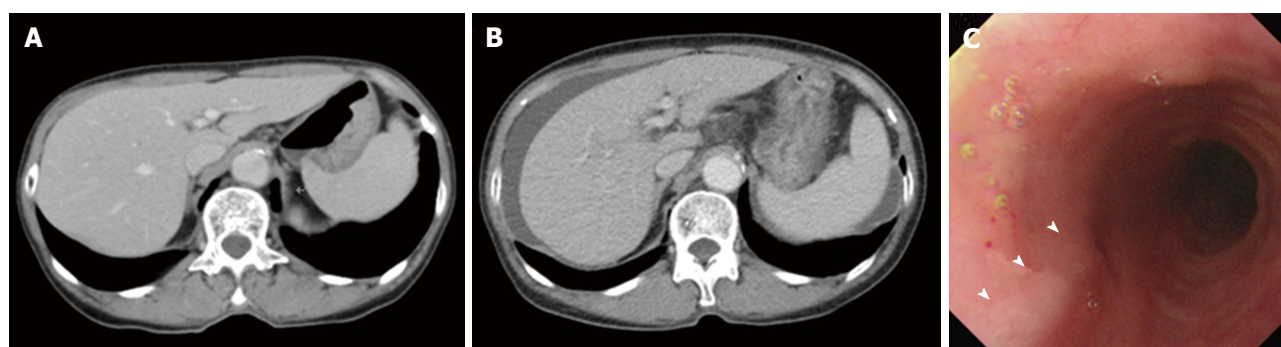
Computed tomography and upper gastrointestinal endoscopy images. A: CT imaging showed neither chronic liver disease nor splenomegaly before breast cancer surgery; B: Eight months after treatment with tegafur-uracil, CT imaging revealed the presence of massive ascites and splenomegaly; C: Upper gastrointestinal endoscopy showed grade 1 esophageal varices (arrowheads).
